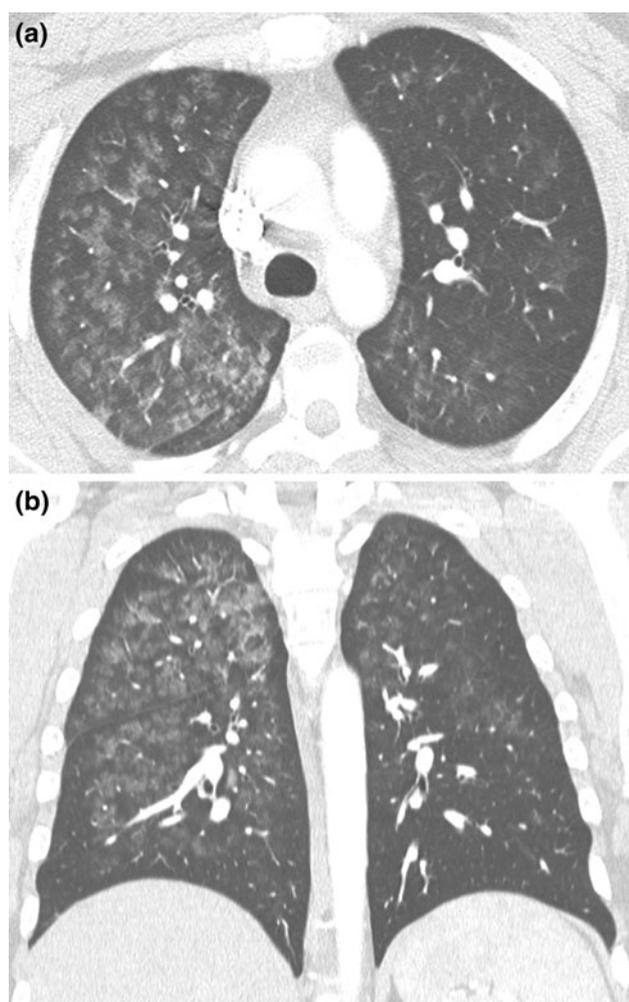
Pulmonary hemorrhage in a 32-year-old man who presented with hemoptysis after 3 months of crack cocaine use. Axial (a) and coronal (b) HRCT images show areas of ground-glass opacity with centrilobular distribution, predominantly in the right lung
